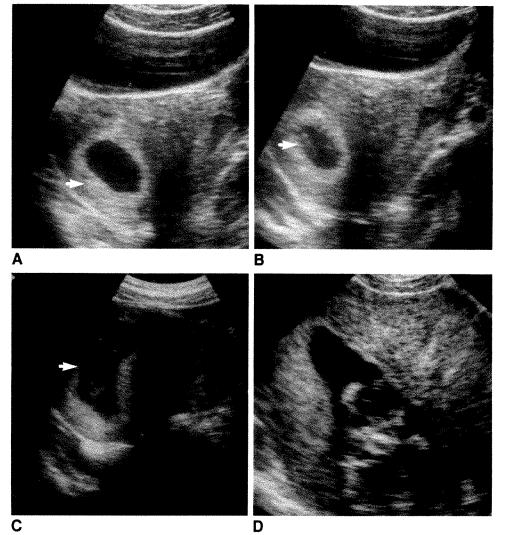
Sonograms show course of pregnancy with lateral implantation in septate uterus.
